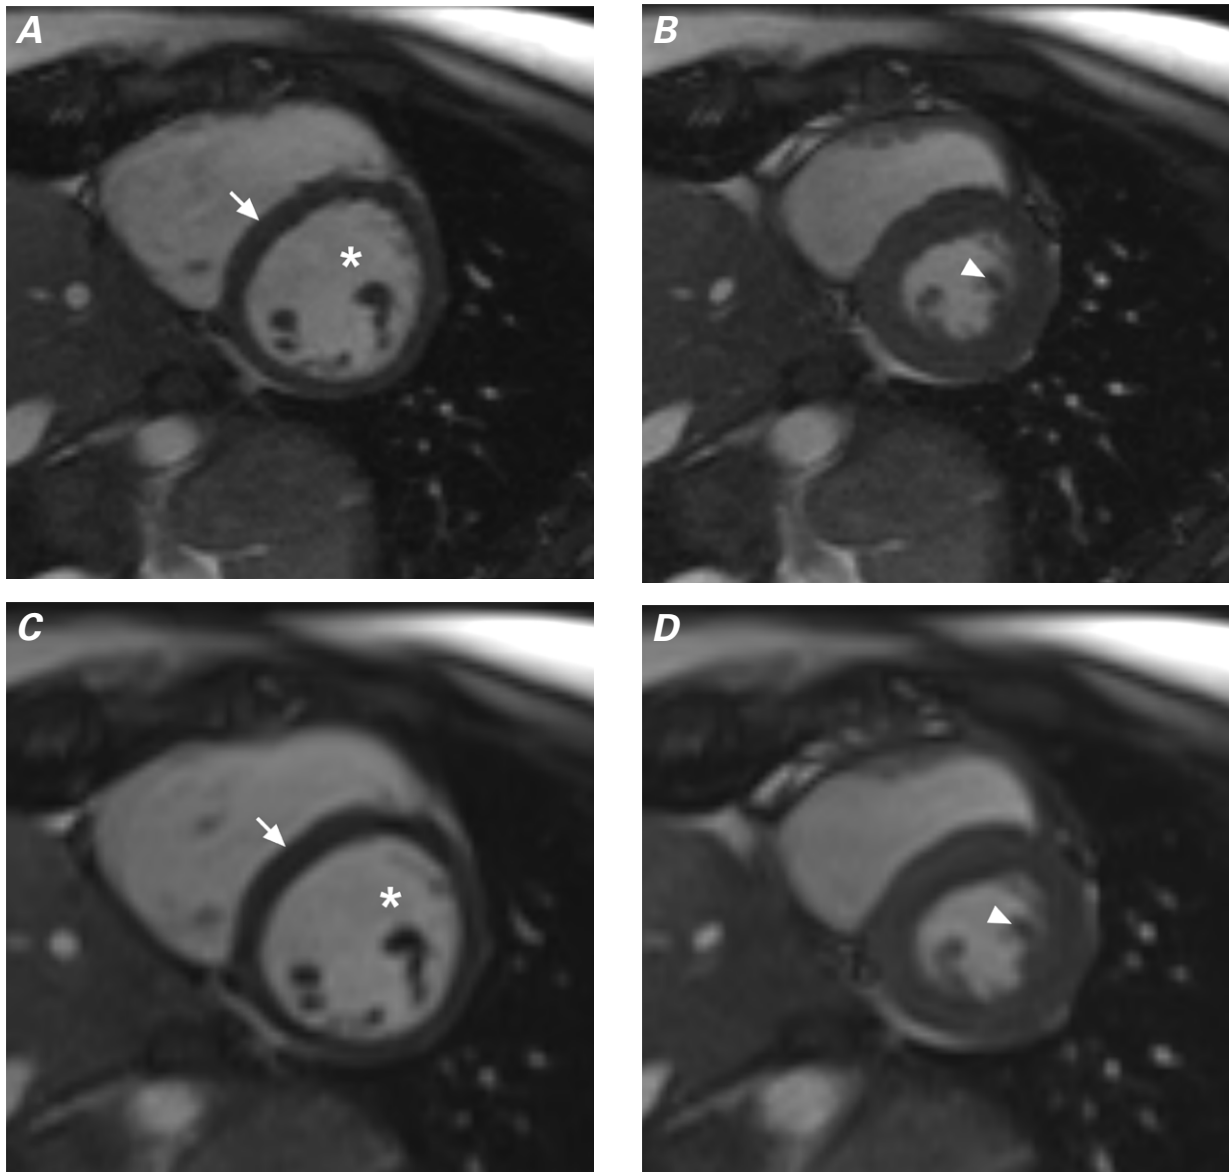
Cardiac magnetic resonance images with steady-state free precession show representative midventricular short-axis slices acquired in A, B multiple- and C, D single-breath-hold sequences during A, C end-diastole and B, D end-systole. Signals were measured for the inferoseptal myocardium (arrows) and left ventricular blood pool (asterisks). Left ventricular trabeculae (arrowheads) were depicted similarly in both methods without visually apparent differences in image quality.
